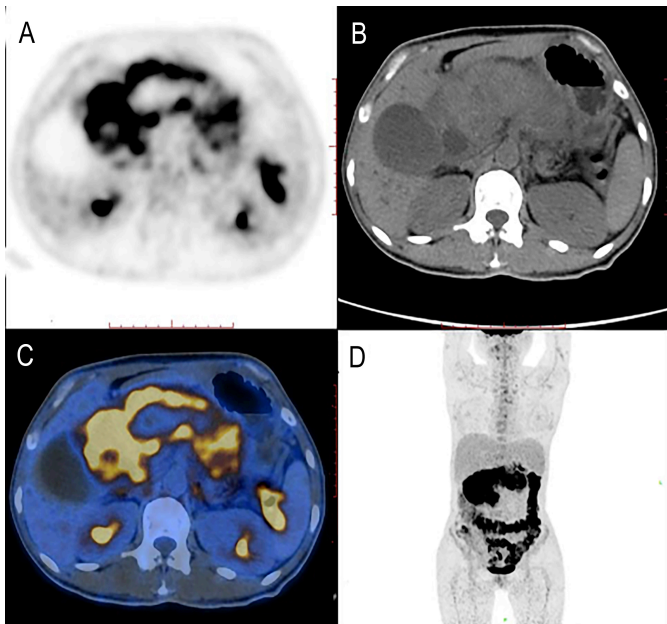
(A-D): 18 F-FDG PET/CT shows diffuse enlargement of the pancreas and increased glucose uptake.
